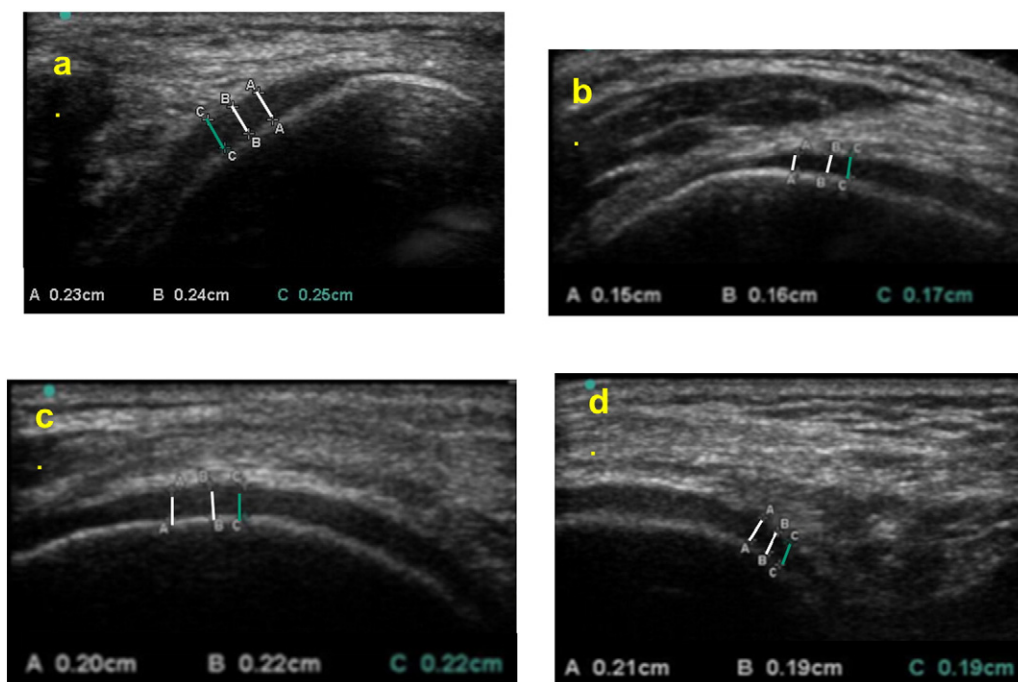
Transverse (a) and longitudinal anterior (b), middle (c), posterior (d) ultrasound images demonstrating three adjacent medial femoral cartilage thicknesses (lines A, B, & C) that were averaged for analyses.
